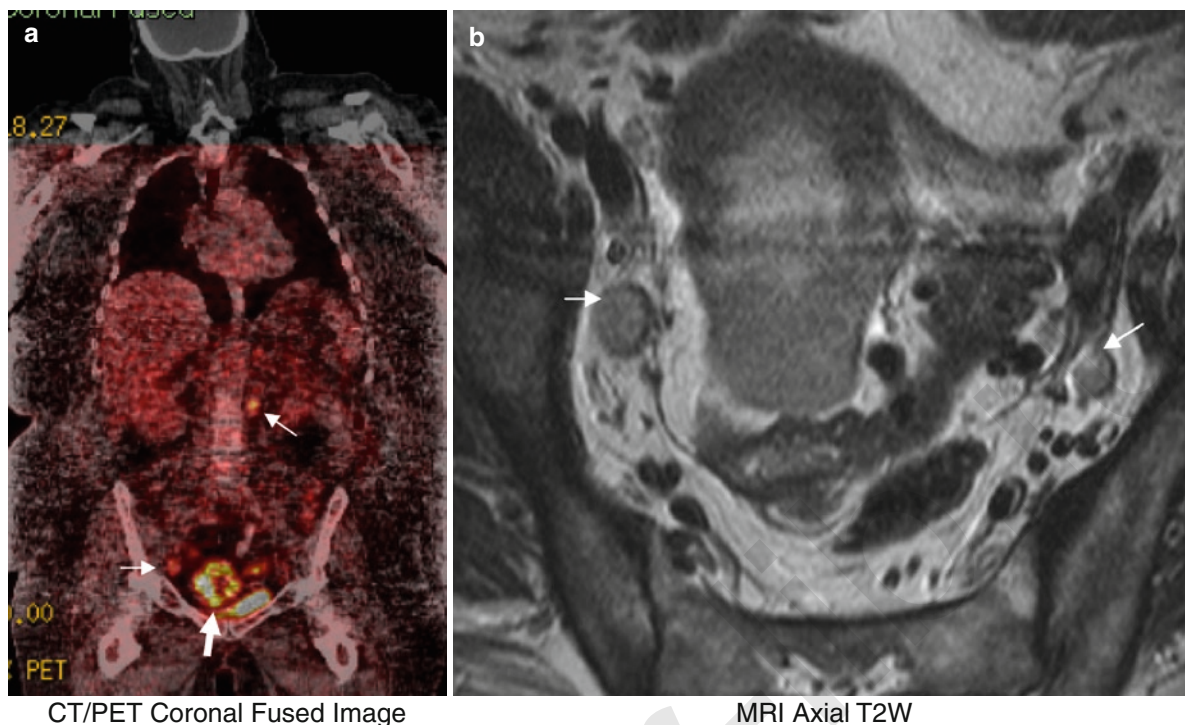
(a) CT/PET coronal fused image. Note poor image quality due to gross obesity. (b) Corresponding MRI T2W axial. Grossly obese patient. High para-aortic node and right obturator node confirmed in patient with Stage 2B cervical carcinoma
